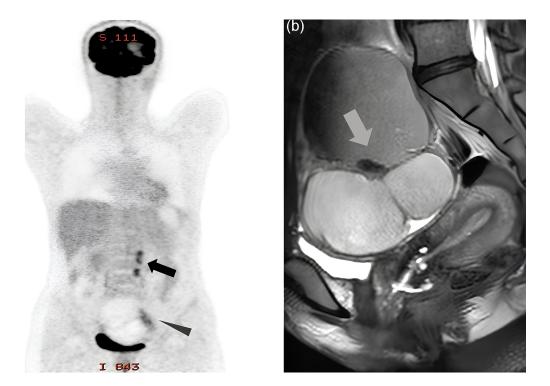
Medical imaging. (a) Accumulation observed in the para-aortic lymph node (\leftarrow) and the left ovarian tumor (\triangleleft). (b) Contrast-enhanced magnetic resonance imaging (T2-weighted imaging): The left ovarian tumor shows liquid components, including fat and hemorrhagic areas, with suspected nodular components (\leftarrow), indicating possible malignant transformation.
